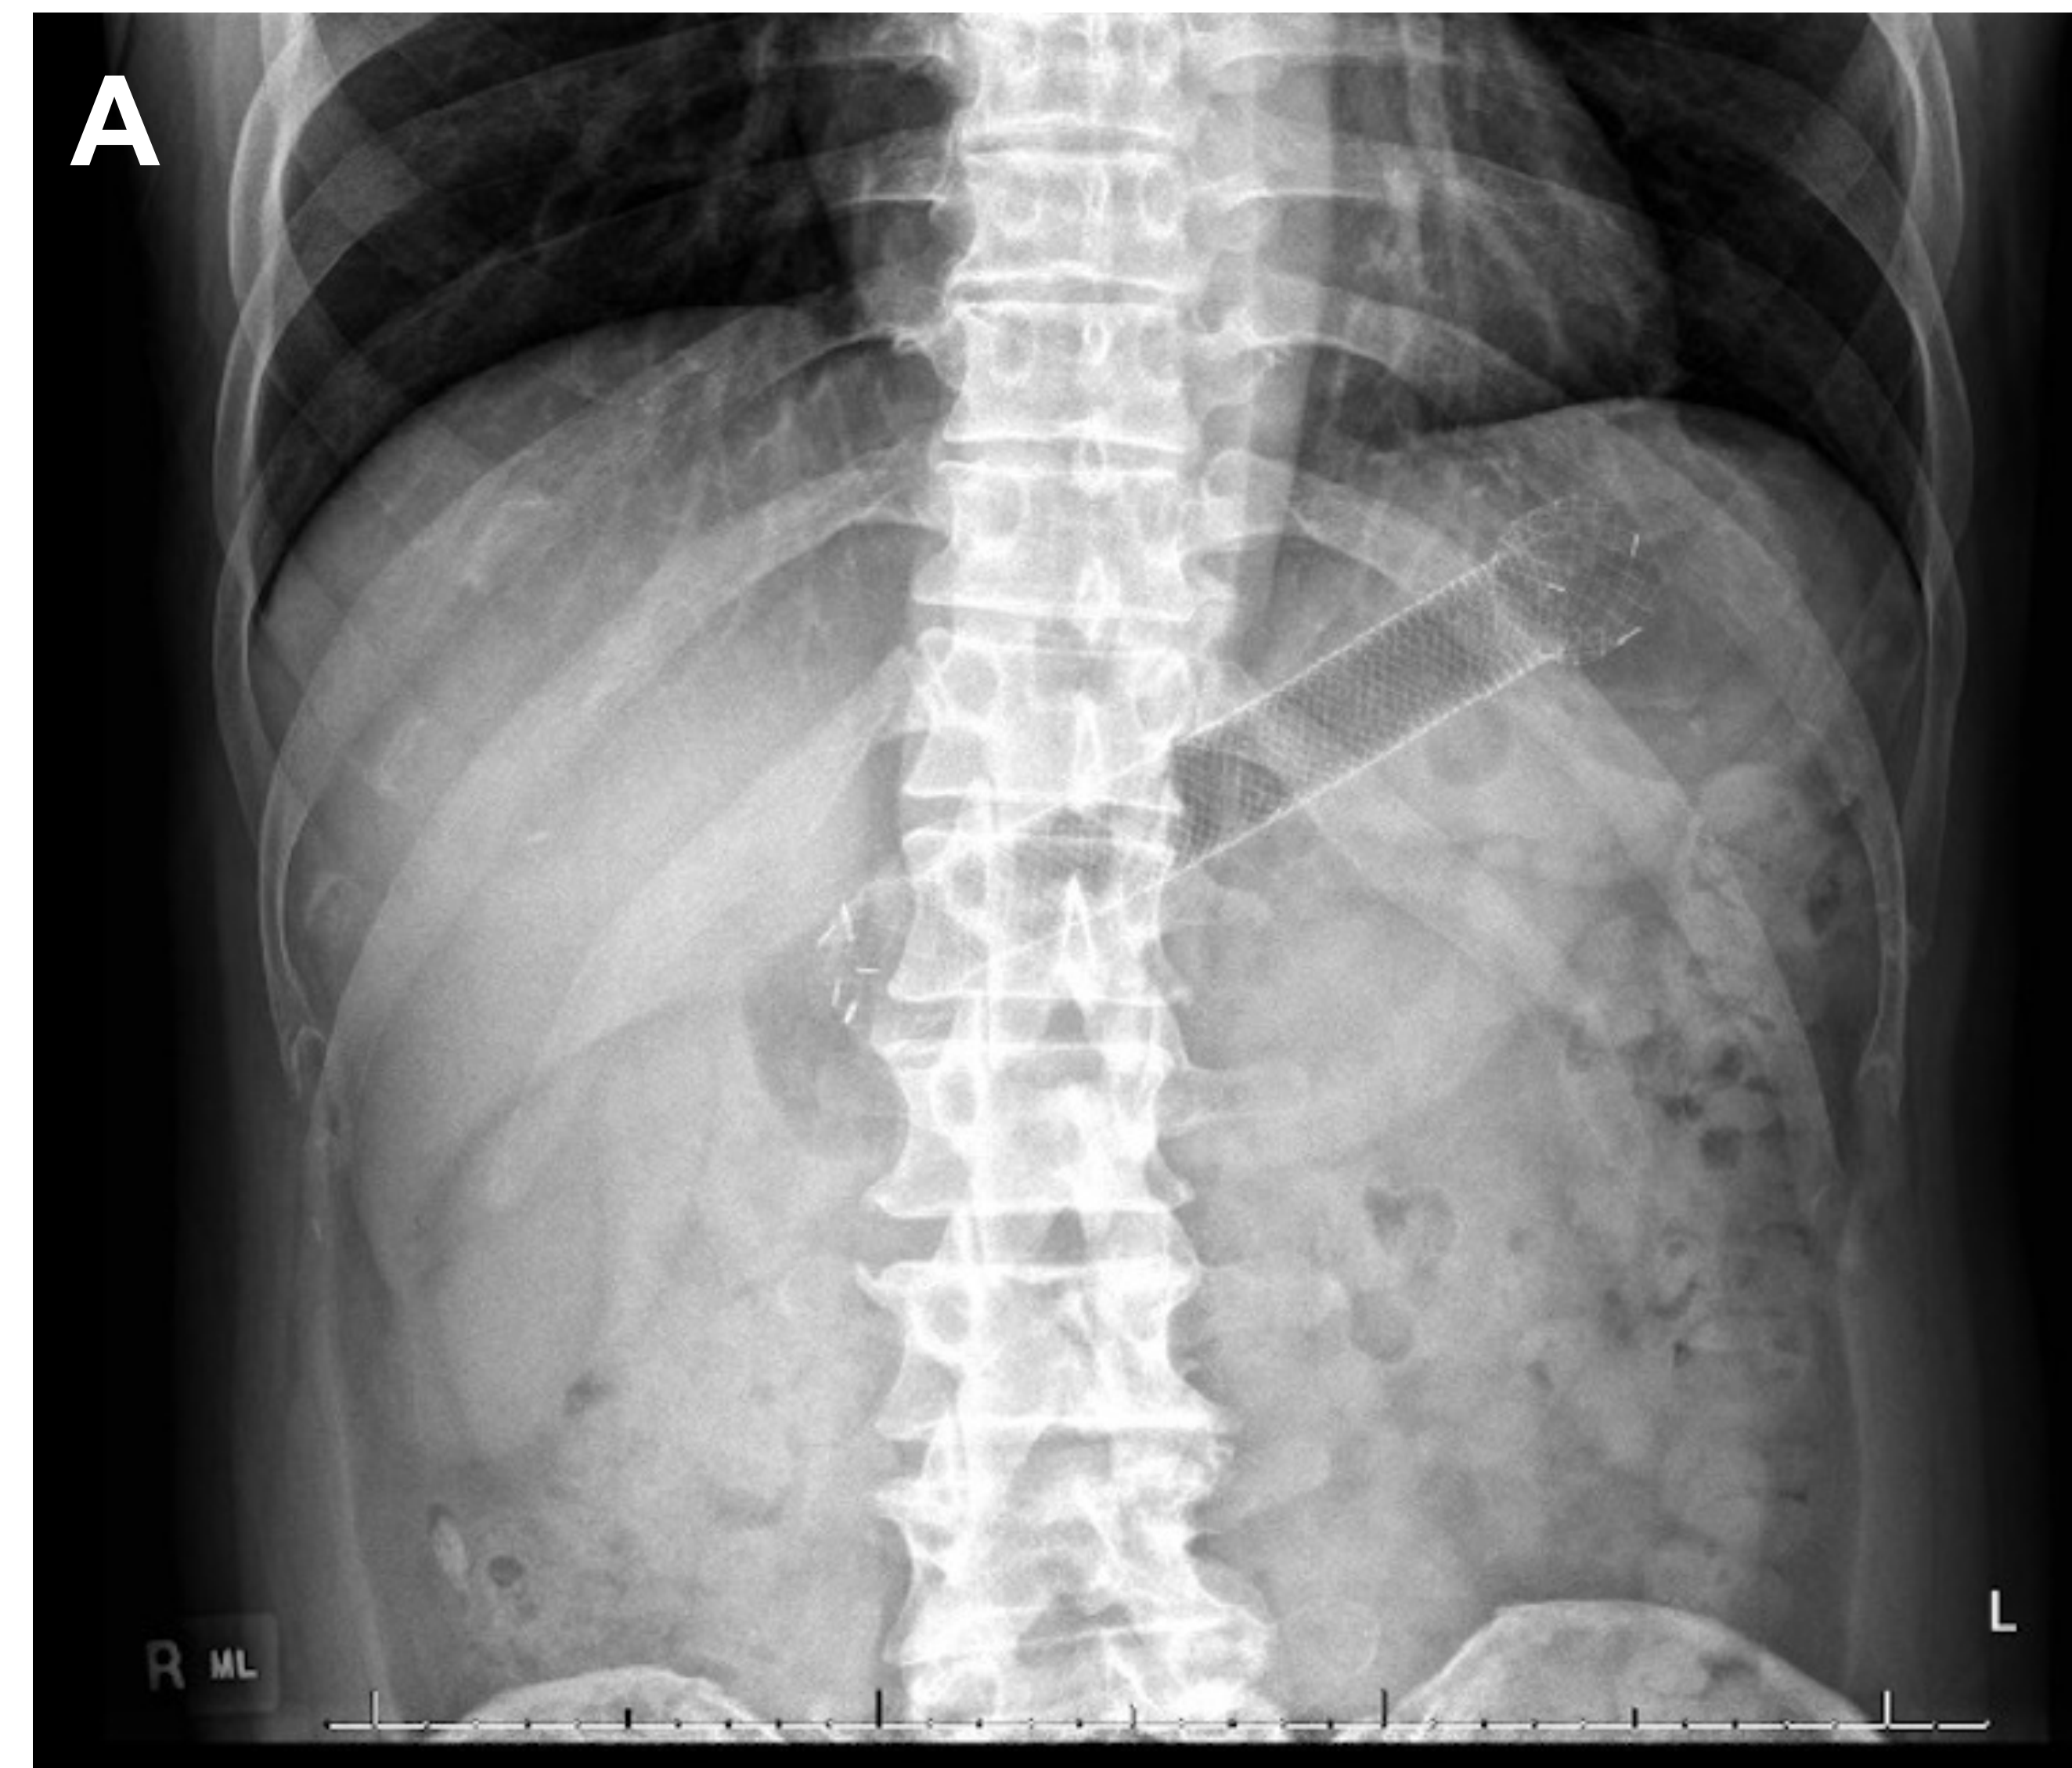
X-ray abdomen and pelvis showing the migrated duodenal stent. Figure B: Endoscopic view of the migrated FCSEMS in the stomach. Figure C: Endoscopic view of the fully deployed LAMS showing the anastomotic connection between the stomach and jejunum, bypassing the duodenal stricture.
